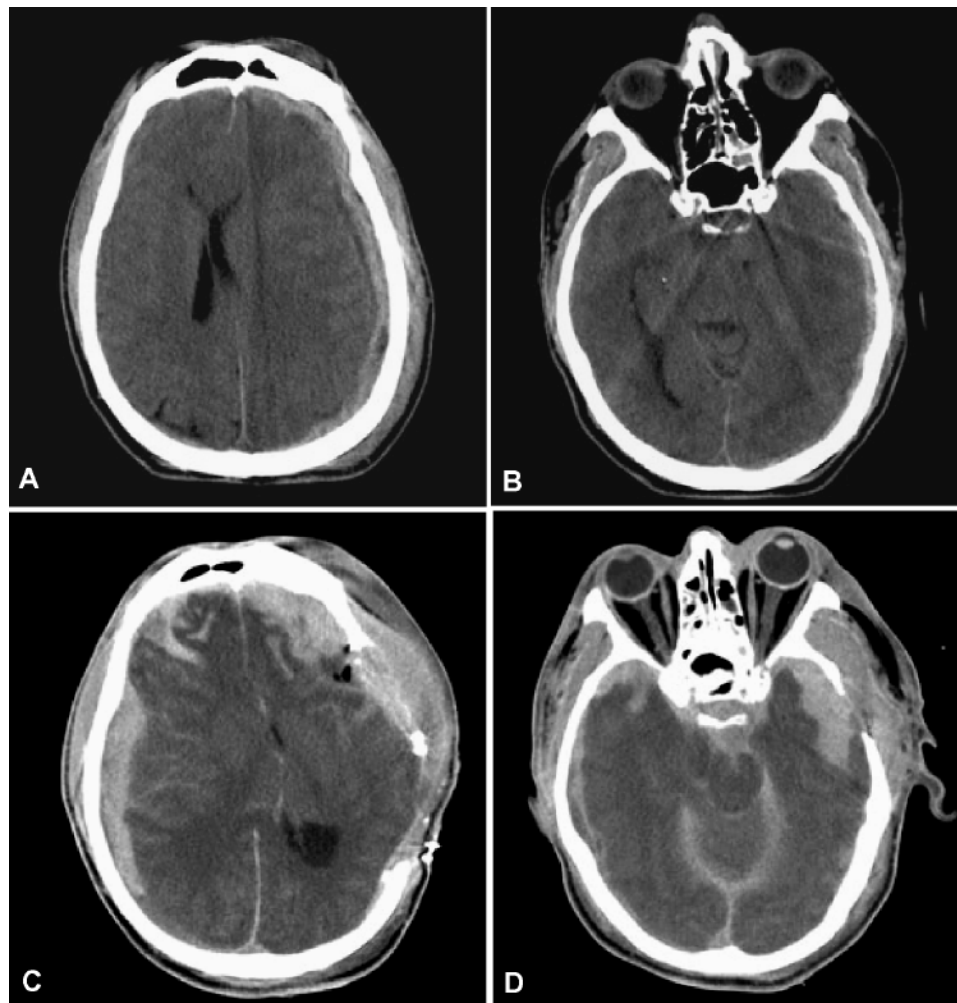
Coagulopathy. Preoperative noncontrast CT scans of an SDH in a patient on a regimen of warfarin (A and B). Despite reversal of the coagulopathy before surgery, marked hemorrhagic blossoming occurred as evidenced by postoperative noncontrast images (C and D). Note in panel C the development of an extraaxial SDH contralateral to the decompressed hemisphere.
